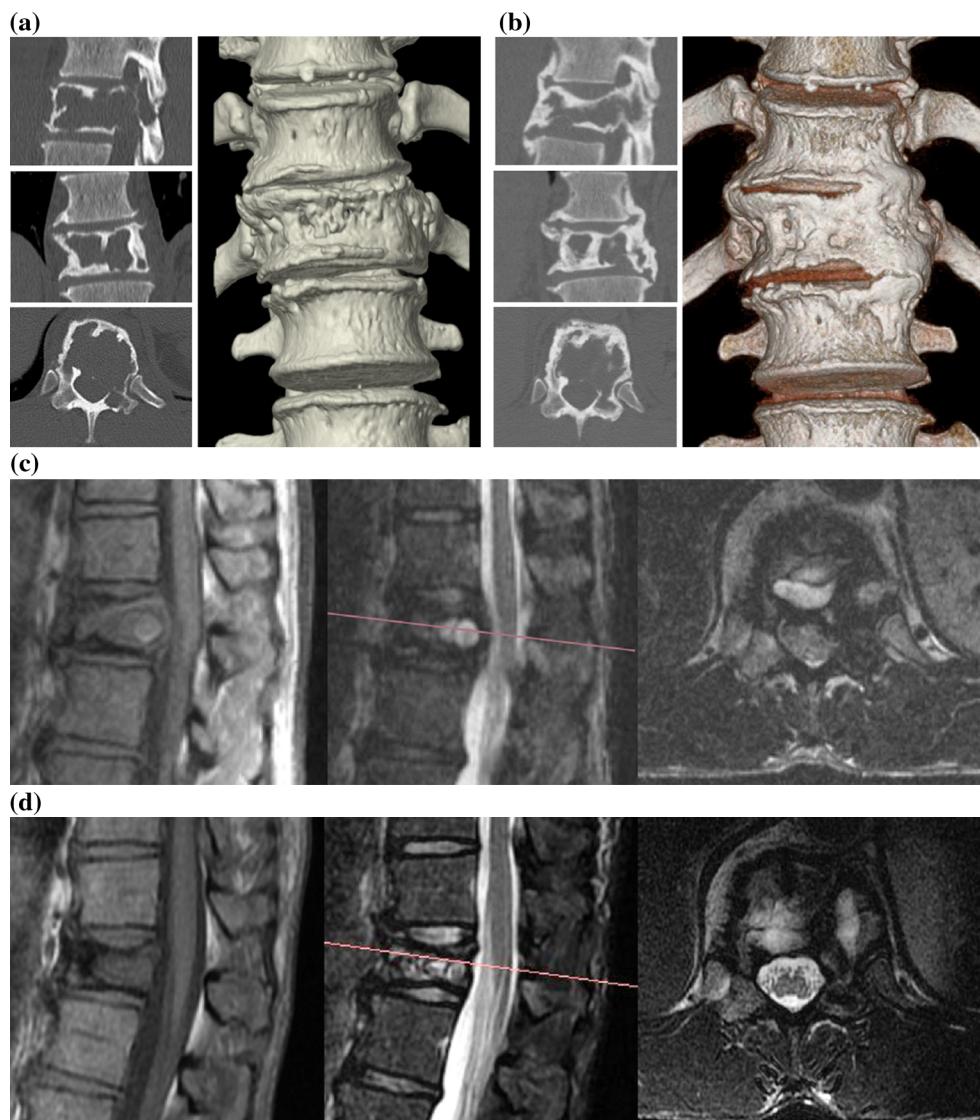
Preoperative computed tomography (Sagittal, coronal, axial and 3D reconstruction) and magnetic resonance imaging (*left* T1-weighted MRI, *middle and right* T2-weighted MRI with fat suppression). a, c Preoperative thoracic magnetic resonance imaging and computed tomography before starting denosumab therapy, showing a
